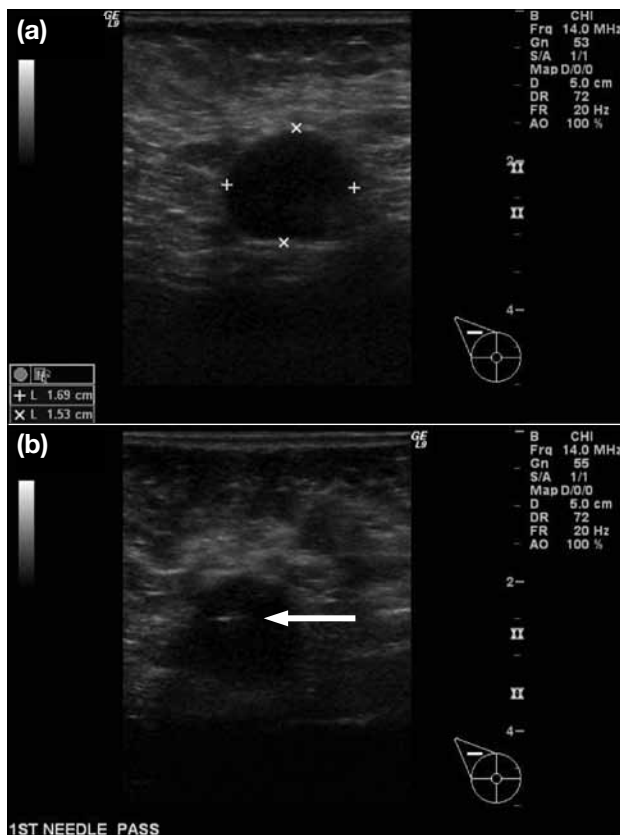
Transverse ultrasound-guided images of malignant axillary lymph node. (a) Image shows loss of fatty hilum with thickened cortex. (b) Ultrasound-guided fine-needle aspiration with tip of needle (arrow) in the suspicious portion of the cortex.
